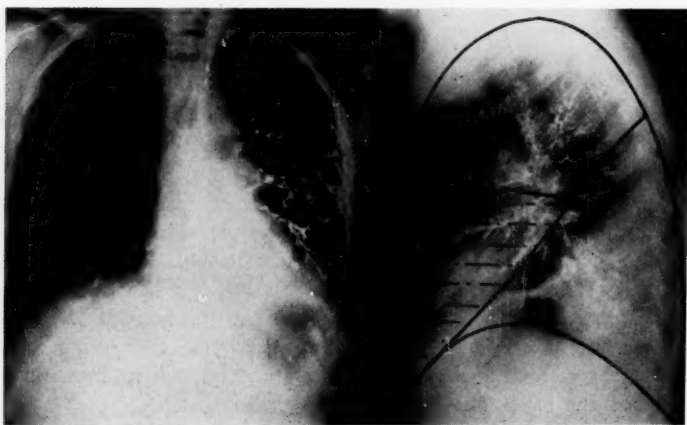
X-ray films showing bronchiectasis of the left lower lobe with associated bronchiectasis of "lingular" segments of the left upper lobe.
